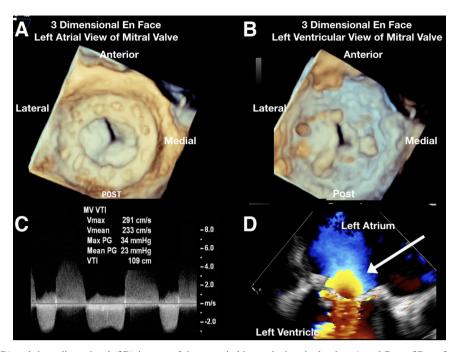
Two-dimensional (2D) and three-dimensional (3D) images of the stenotic bioprosthetic mitral valve. A and B are 3D en-face views of the bioprosthetic mitral valve from the perspective of the left atrium (A) and left ventricle (B). (C) Continuous-wave Doppler assessment of transmitral flows showing a peak and mean gradient of 34 and 23 mmHg, respectively. (D) A 2D color Doppler flow across the stenotic valve from the midesophageal two-chamber window. The white arrow points to the flow convergence consistent with stenosis.
